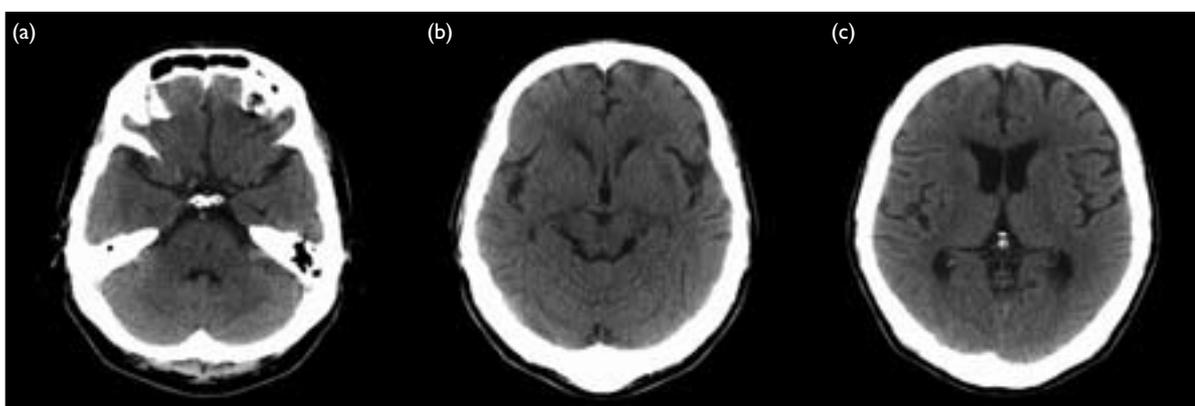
Follow-up computed tomographic scans of the brain at 6 weeks show complete resolution of the pons and midbrain lesions (a, b) with minimal residual changes in the periventricular white matter (c)
